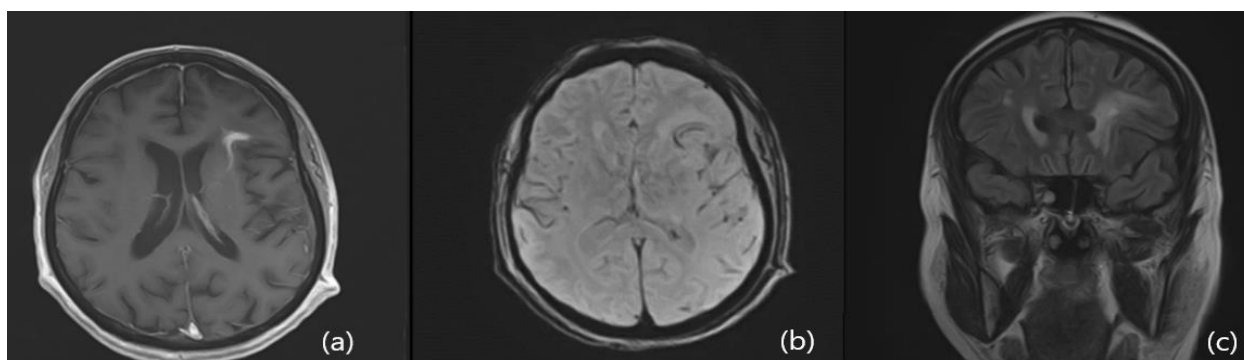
MRI brain with contrast (a) T1 image showing interval reduction in the ring enhancing lesion there is change in enhancement pattern, now seen as curvilinear intense enhancement (b) T2/FLAIR imaging showing linear subcortical abnormal signal intensity with intralesional hypo-intensity showing reduced size and improvement in diffusion restriction. (c) T1 coronal view showing reduced perilesional oedema and gyral swelling.
